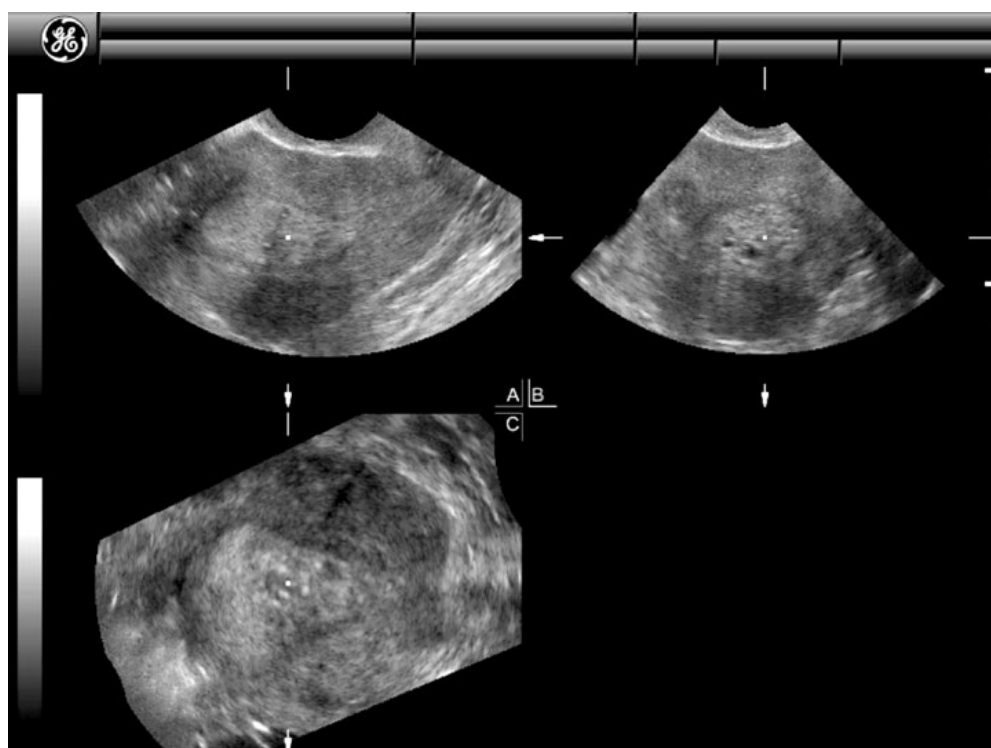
A three-dimensional ultrasound image of the uterus in Patient no. 18, with no deep invasion, demonstrating sagittal (A), transverse (B) and rendered coronal planes (C) of the 'Sectional planes' utility. When moving through planes A and B, the margins of the endometrial tumor can be assessed thoroughly.
